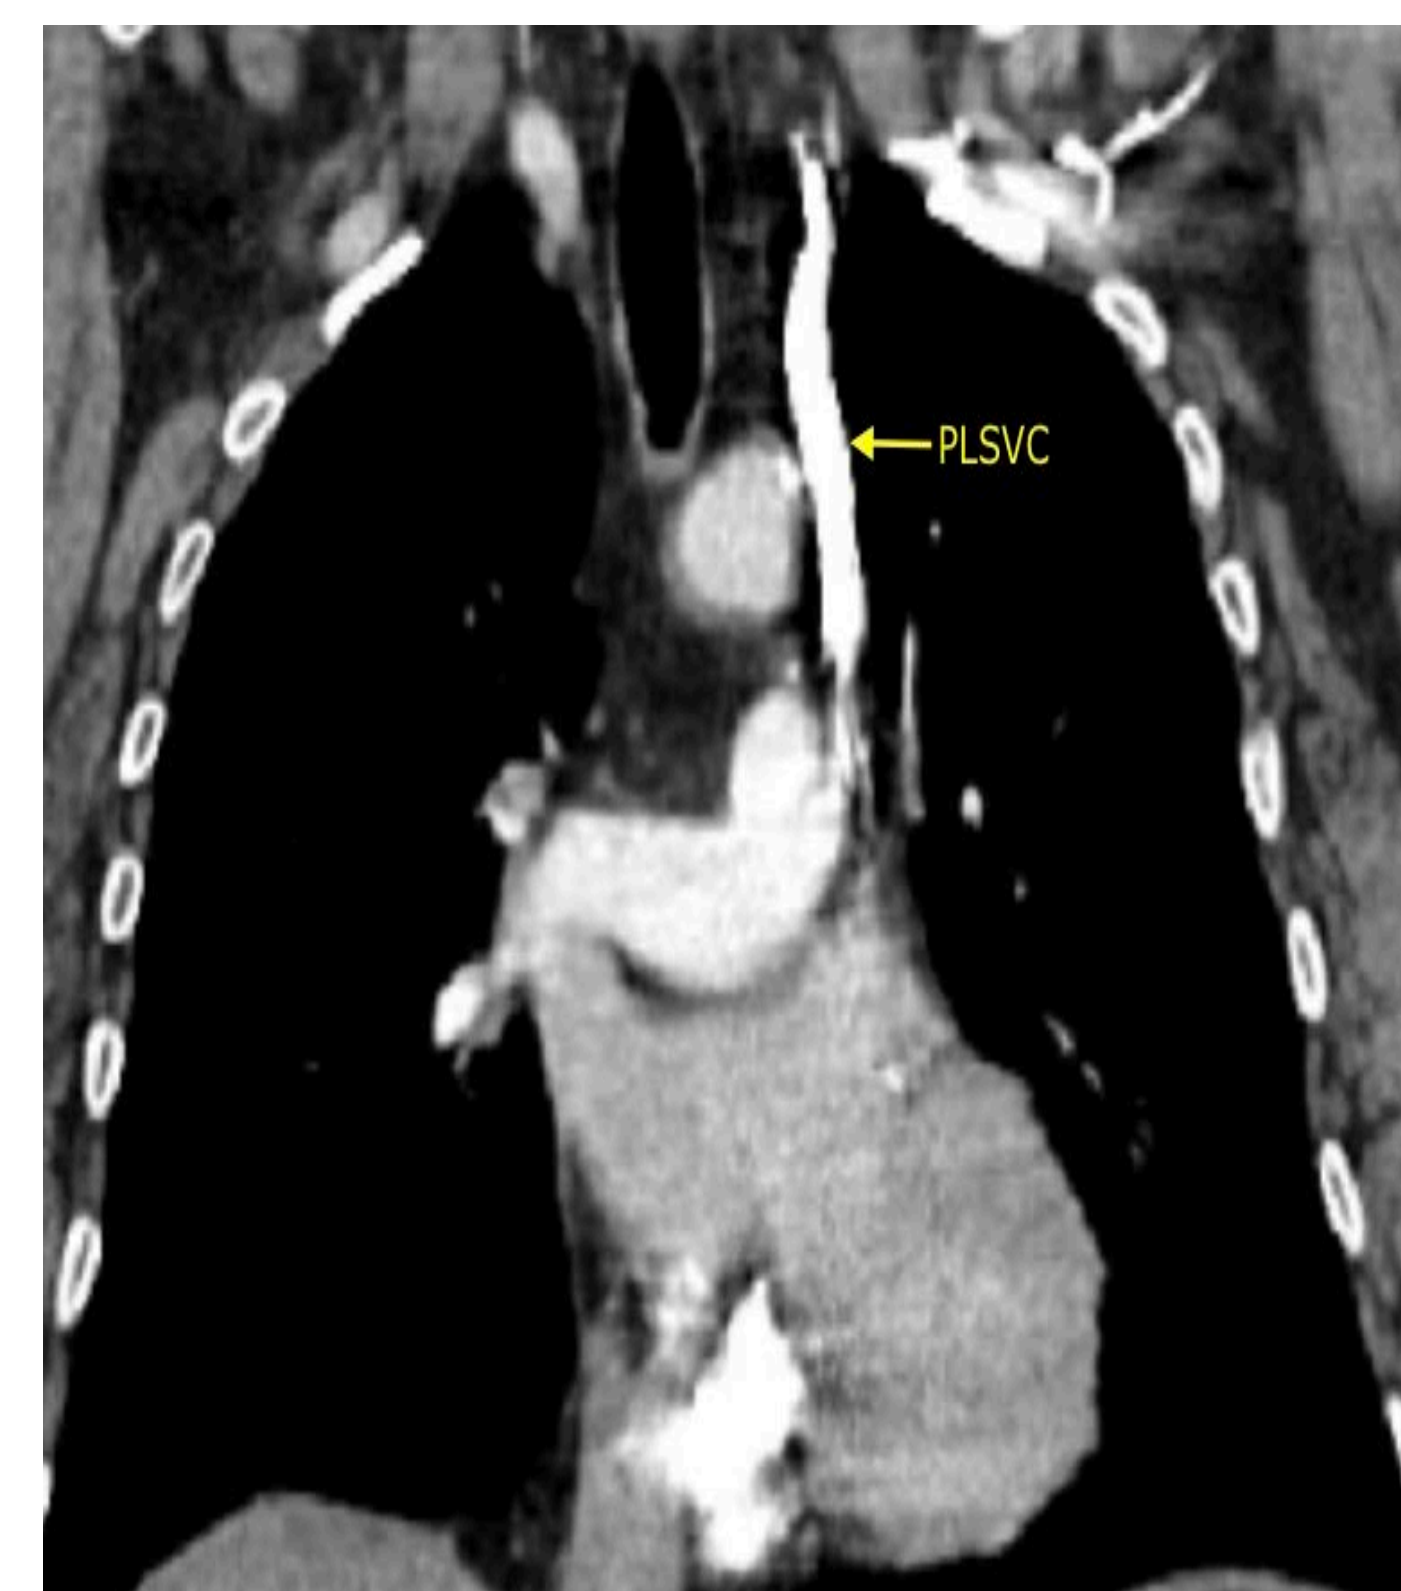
CT Chest showing persistent LSV
